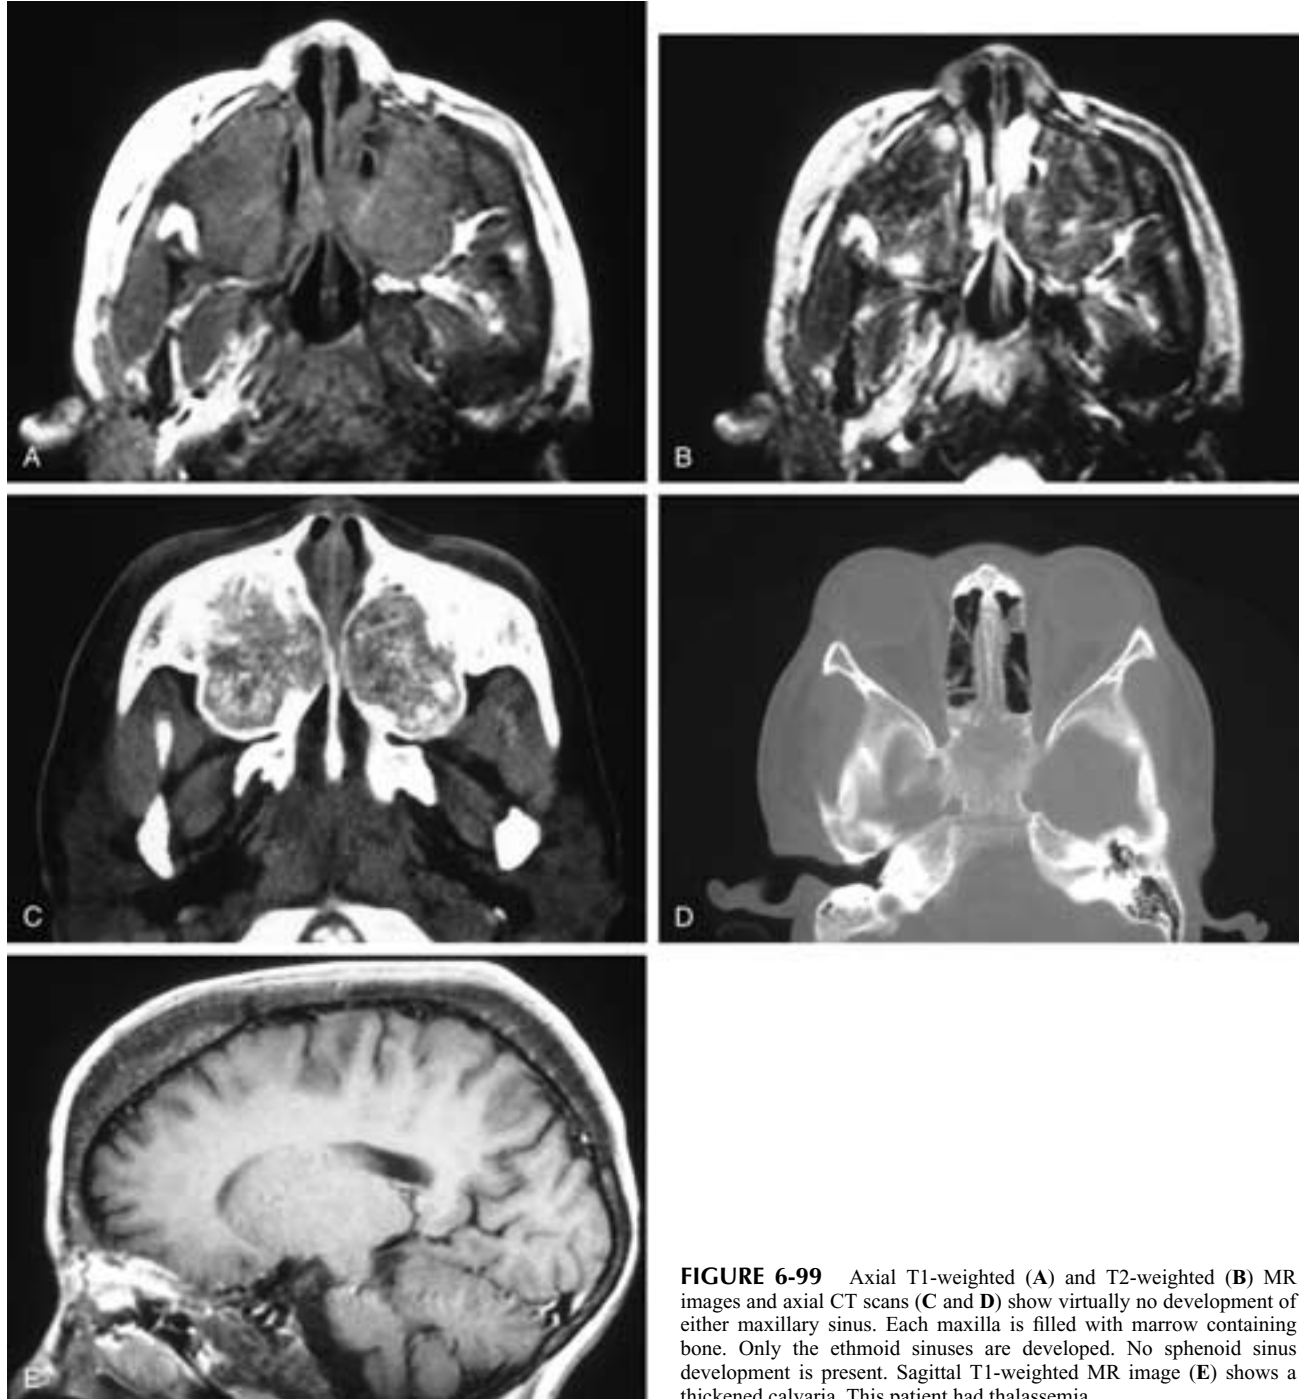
Axial T1-weighted (A) and T2-weighted (B) MR images and axial CT scans (C and D) show virtually no development of either maxillary sinus. Each maxilla is filled with marrow containing bone. Only the ethmoid sinuses are developed. No sphenoid sinus development is present. Sagittal T1-weighted MR image (E) shows a thickened calvaria. This patient had thalassemia.
